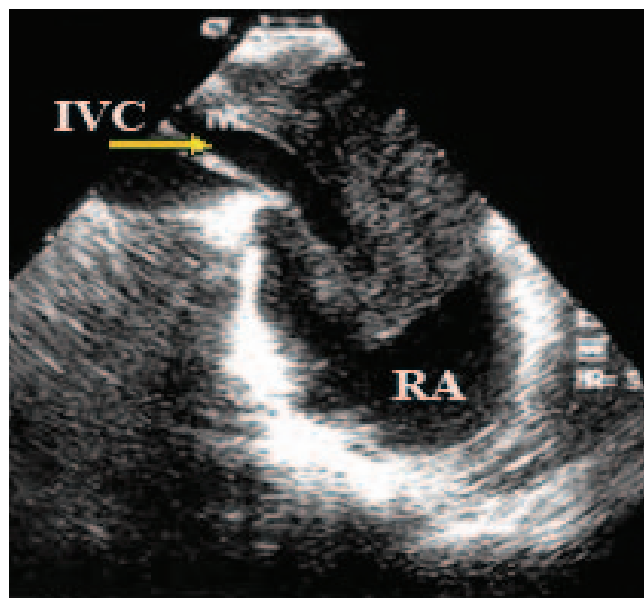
Intracardiac leiomyomatosis; transesophageal view of intracardiac leiomyomatosis invading right atrium (RA) by dilated inferior vena cava (IVC). Tumor is heterogeneous in appearance and abuts superior border of IVC (arrow).
